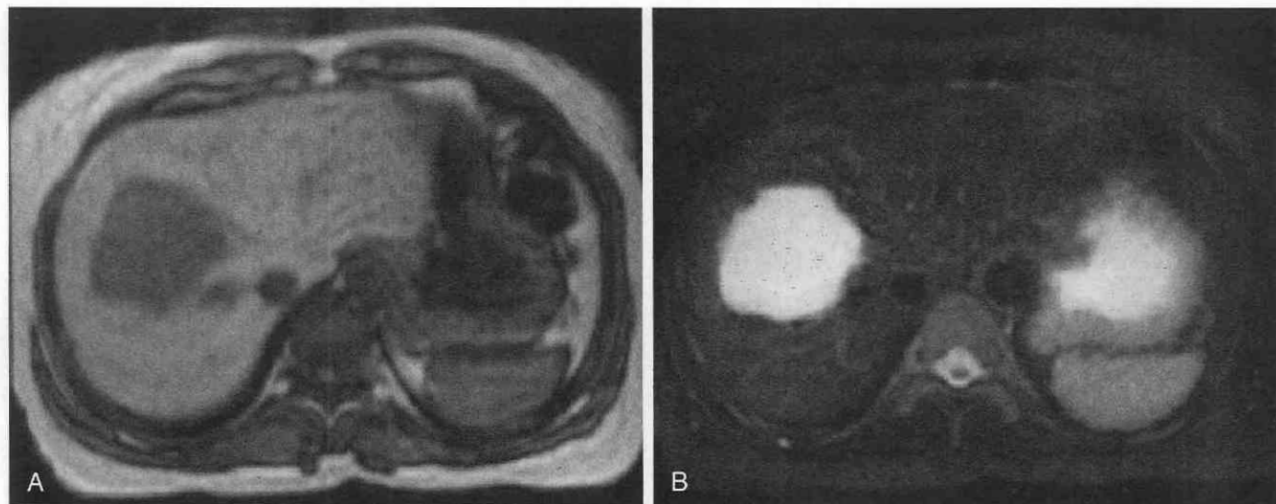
Hemangioma. A, Unenhanced T1-weighted image demonstrates a large lesion in the right hepatic lobe with low signal intensity. B, Unenhanced T2-weighted image demonstrates very high signal intensity, or a “light bulb” appearance.
